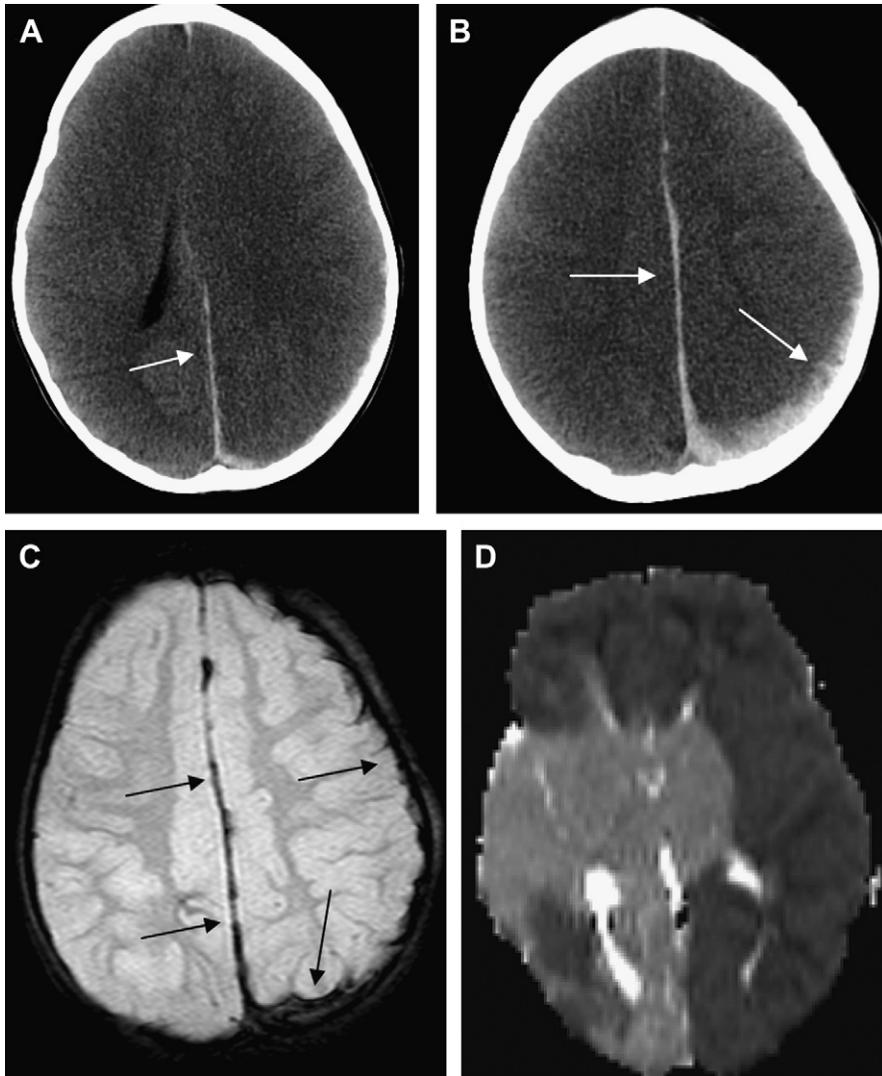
Twenty-one-month-old toddler with triad and alleged NAI; also, history of prior head impact. Question prior injury with lucid interval versus hyperacute injury. CT (A, B) acute left convexity and interhemispheric SDH and SAH (arrows) with cerebral swelling, left more than right. T2* MR imaging (C) shows low intensity SDH (arrows) with T1/T2 isointensity (not shown). ADC map (D) shows asymmetric cerebral restricted diffusion (left > right). Autopsy confirms impact with acute SDH, SAH, and hypoxic-ischemic injury.
